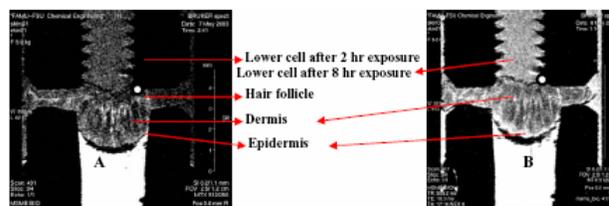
The figure shows distinct epidermis, dermis and hair follicles in post treatment skin images by using two different methods of contrast T1 weighted (panel A), T2 weighted (panel B) after 6 hours to analyze MRI signal intensities as shown in Table 1 as guide to compare the MRI signal intensities.
